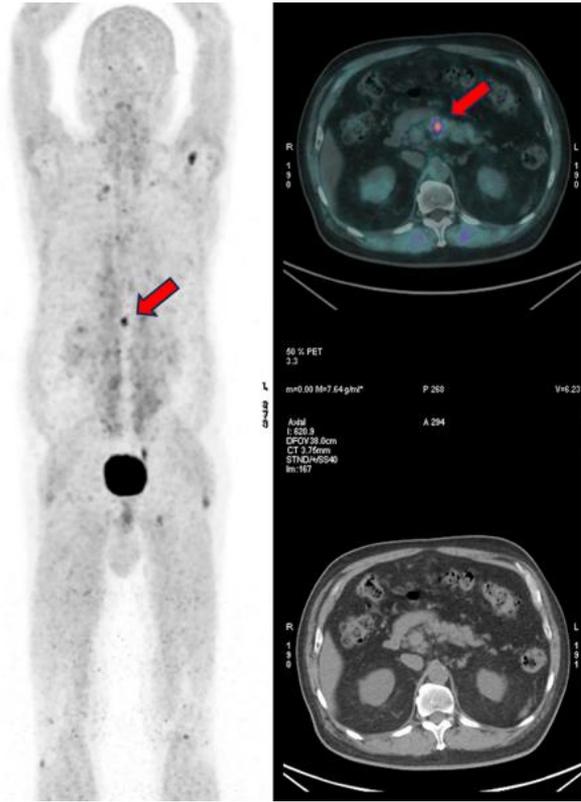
^{68}Ga -FAPI PET/CT.
